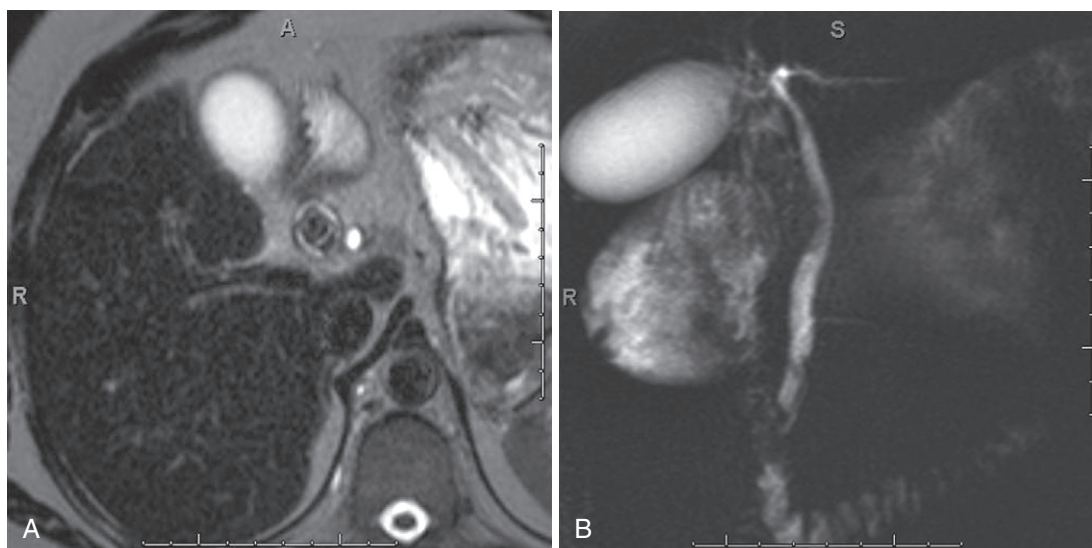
Mirizzi's syndrome. T2-weighted (A) and coronal thick-slab MIP MRCP (B) images demonstrate multiple stones in the cystic duct causing extrinsic compression of the adjacent common hepatic duct in this patient with Mirizzi's syndrome.
